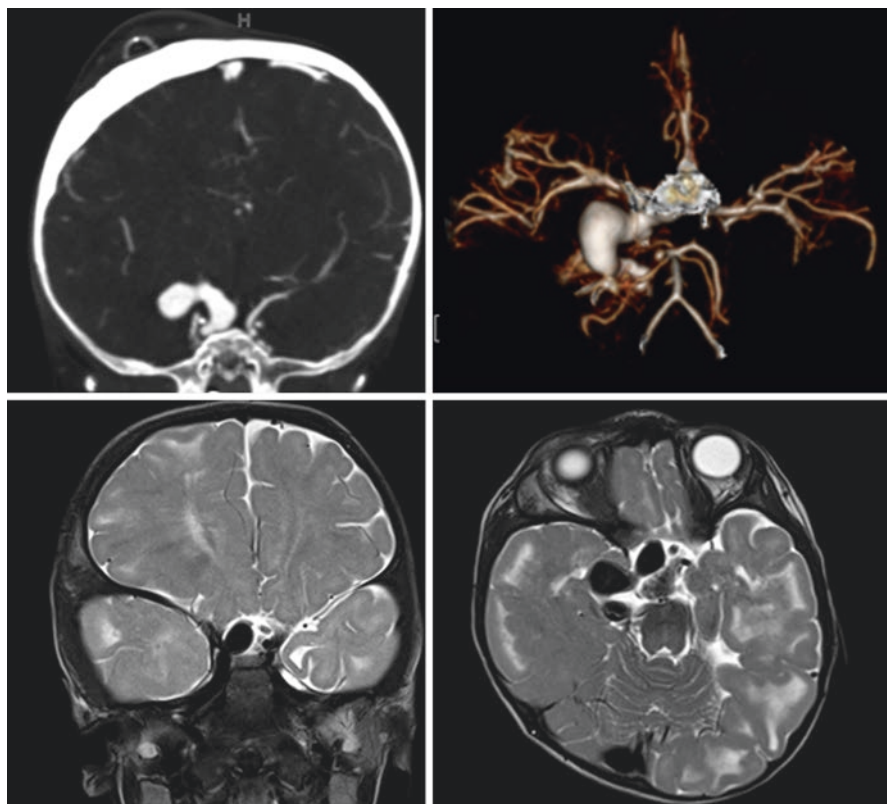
Nineteen-month-old girl with confirmed tuberous sclerosis complex. A large lobulated/fusiform distal internal carotid artery aneurysm is seen extending into the region of the proximal right middle cerebral artery. The aneurysm is well demarcated on the contrast enhanced CTA and on the matching contrast enhanced 3D CTA-reconstruction. On T2-weighted MR images the aneurysm appears hypointense due to the flow void. The characteristic stigmata of tuberous sclerosis complex are noted within the brain parenchyma bilaterally
